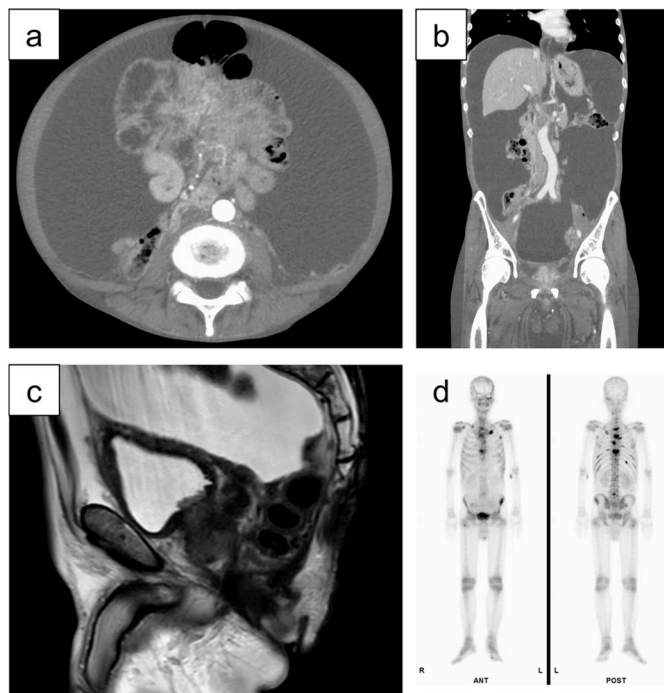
(a and b) CT imaging shows prominent ascites and thickening of the mesentery. No apparent tumor can be identified in the peritoneal cavity. (c) MRI shows cT3b prostate cancer directly invading seminal vesicles and the urinary bladder but not the peritoneal cavity. (d) Bone scan revealed metastasis to the sternum, ribs, and pelvis.
